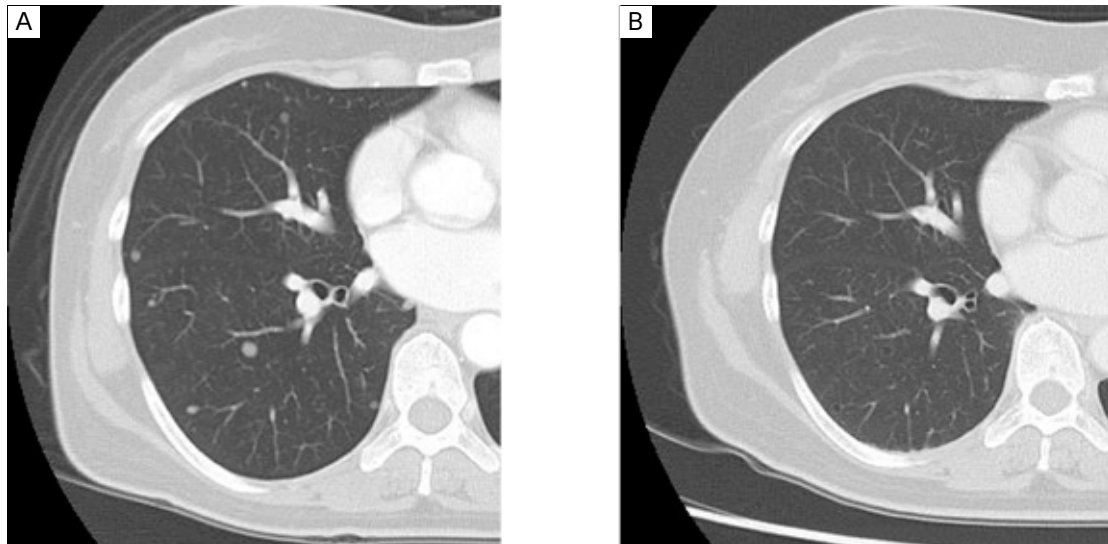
Chest computed tomography (CT) reveals multiple small, solid bilateral pulmonary nodules (A), the disappearance of most of the solid tumor, multiple thin-walled cystic lesions (B).
